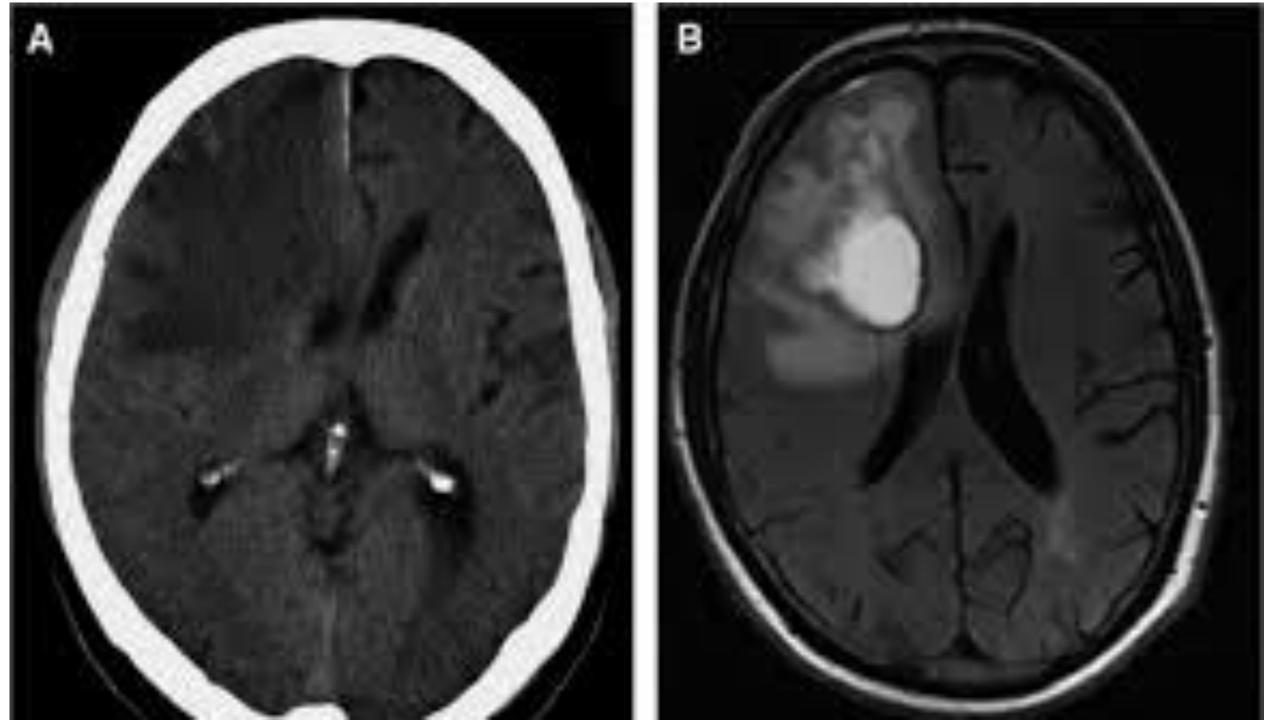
Glioblastoma multiforme. A: Contrast-enhanced T1-weighted image shows enhancing necrotic lesion. B: Contrast-enhanced FLAIR shows enhancing necrotic tumor as well as surrounding vasogenic edema.
